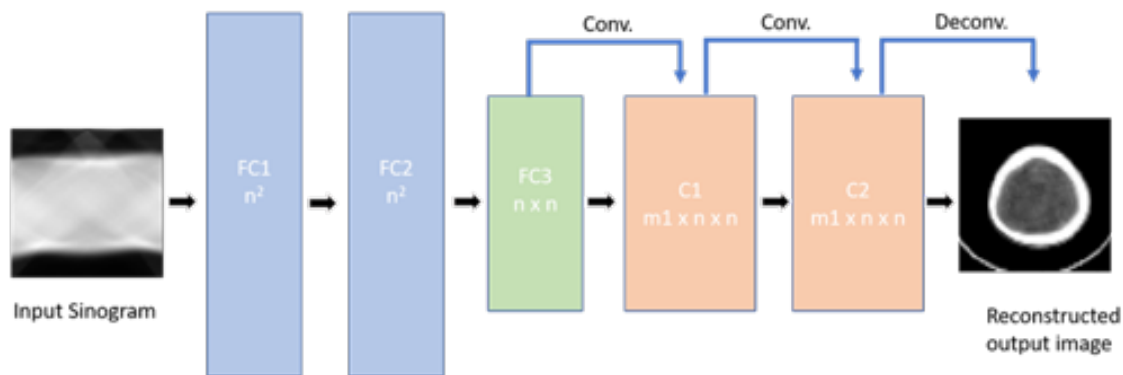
Layers of AUTOMAP, as used for CT
